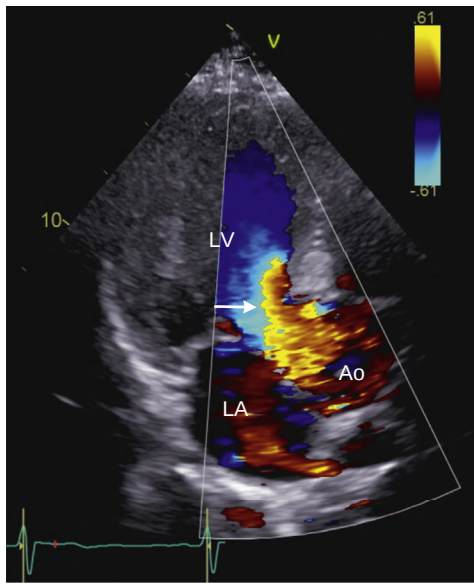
Color Doppler signal aliasing. In this apical long-axis view, the antegrade flow in the LV outflow tract, away from the transducer, aliases from blue to red because velocity exceeds the Nyquist limit of 61 cm/s. The shape of the aliasing transition across the outflow tract also depends in the exact angle between the ultrasound beam and blood flow stream; a nonparallel intercept angle underestimates velocity, so aliasing occurs closer to the aortic valve even when velocities are uniform across the outflow tract. Ao, Aorta.
